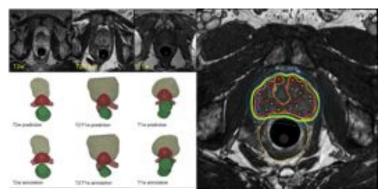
(Left) Autosegmentation examples in multi-contrast MRIs. (Right) Automated postimplant dosimetry after MRI-based LDRPBT.
